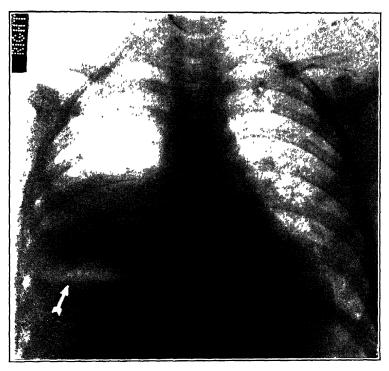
Case 1 Chest roentgenogram showing gas and fluid level beneath right leaf of diaphragm. This was noted 8 months after a diagnosis of appendicitis. At this time, patient was sent to hospital because of a diagnosis of pulmonary disease. (Anspach: J. Pediat.)
